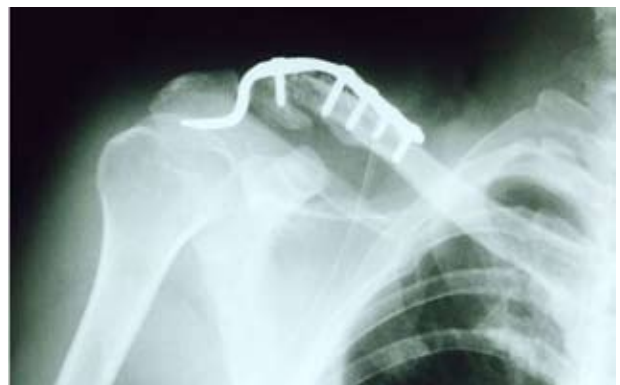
A postoperative radiograph presenting the distal clavicle which was fixed by using a 6-hole hook plate with 4 screws in the medial part and a single screw in the lateral part.
